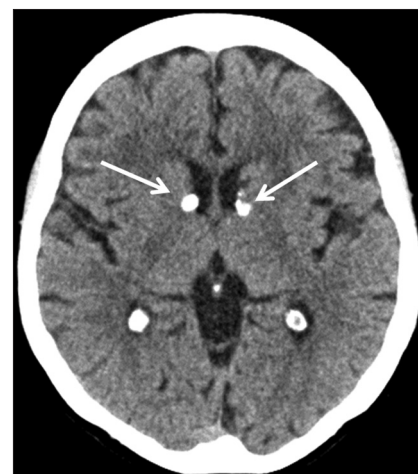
Unenhanced computed tomography head shows bilateral calcified subependymal nodules (white arrows), classically located along the striothalamic groove of the lateral ventricles
